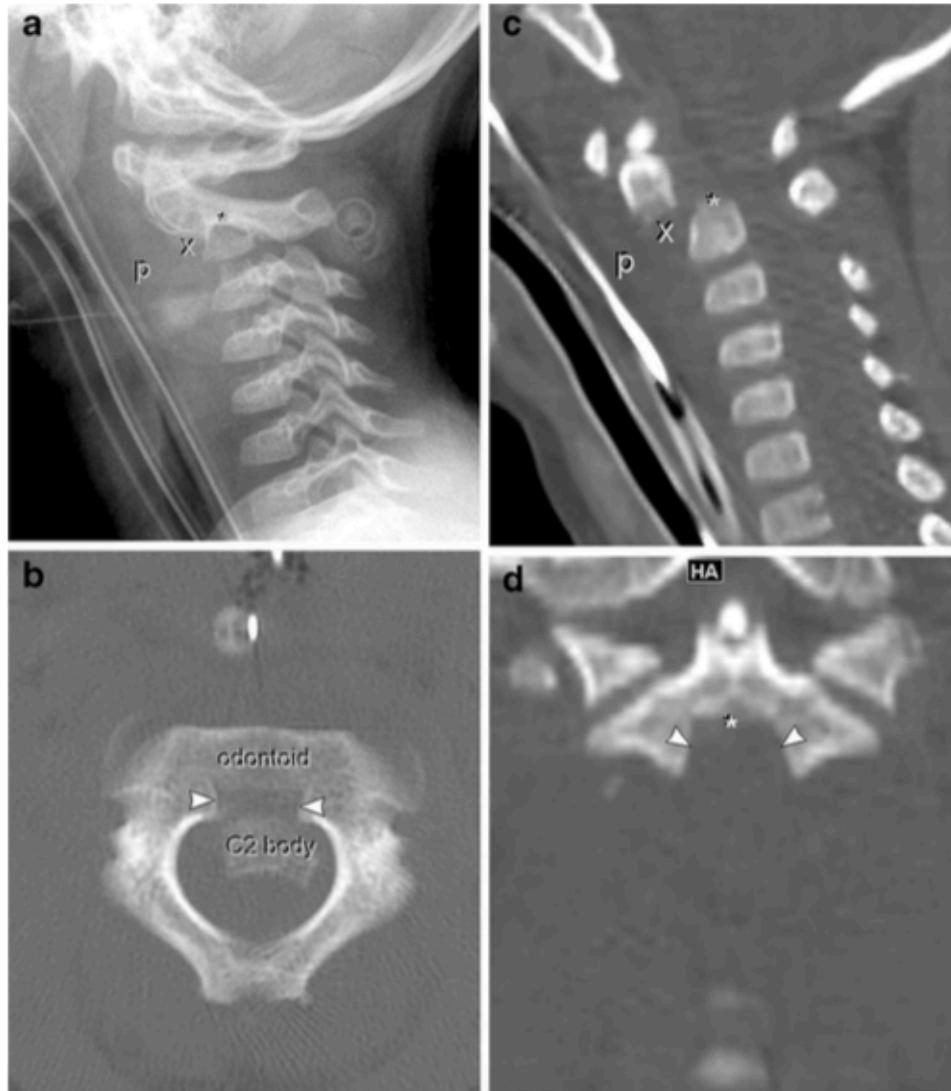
Type II subtype c fracture in patient 1, a 4-year-old female after a motor vehicle crash. (a) Lateral radiograph, (b) axial CT, (c) sagittal (lateral view) CT and (d) coronal CT reformation images show fractures involving the right and left neurocentral (arrowheads) and the odontocentral synchondroses (*) with 100% anterior displacement (x) and marked pre-vertebral edema (p). C2 ring and odontoid are displaced anteriorly relative to the C2 body (C2 body). (d) Coronal CT image shows a rocket sign consisting of the C2 body being punched out from the rest of C2 leaving the neural arches and dens as one unit in the shape of a rocket on a launching pad. MRI (not shown) revealed spinal cord and tectal membrane injury, mild atlanto-occipital dissociation and a clival hematoma. This patient was treated with primary C1-3 cerclage wire fixation.
